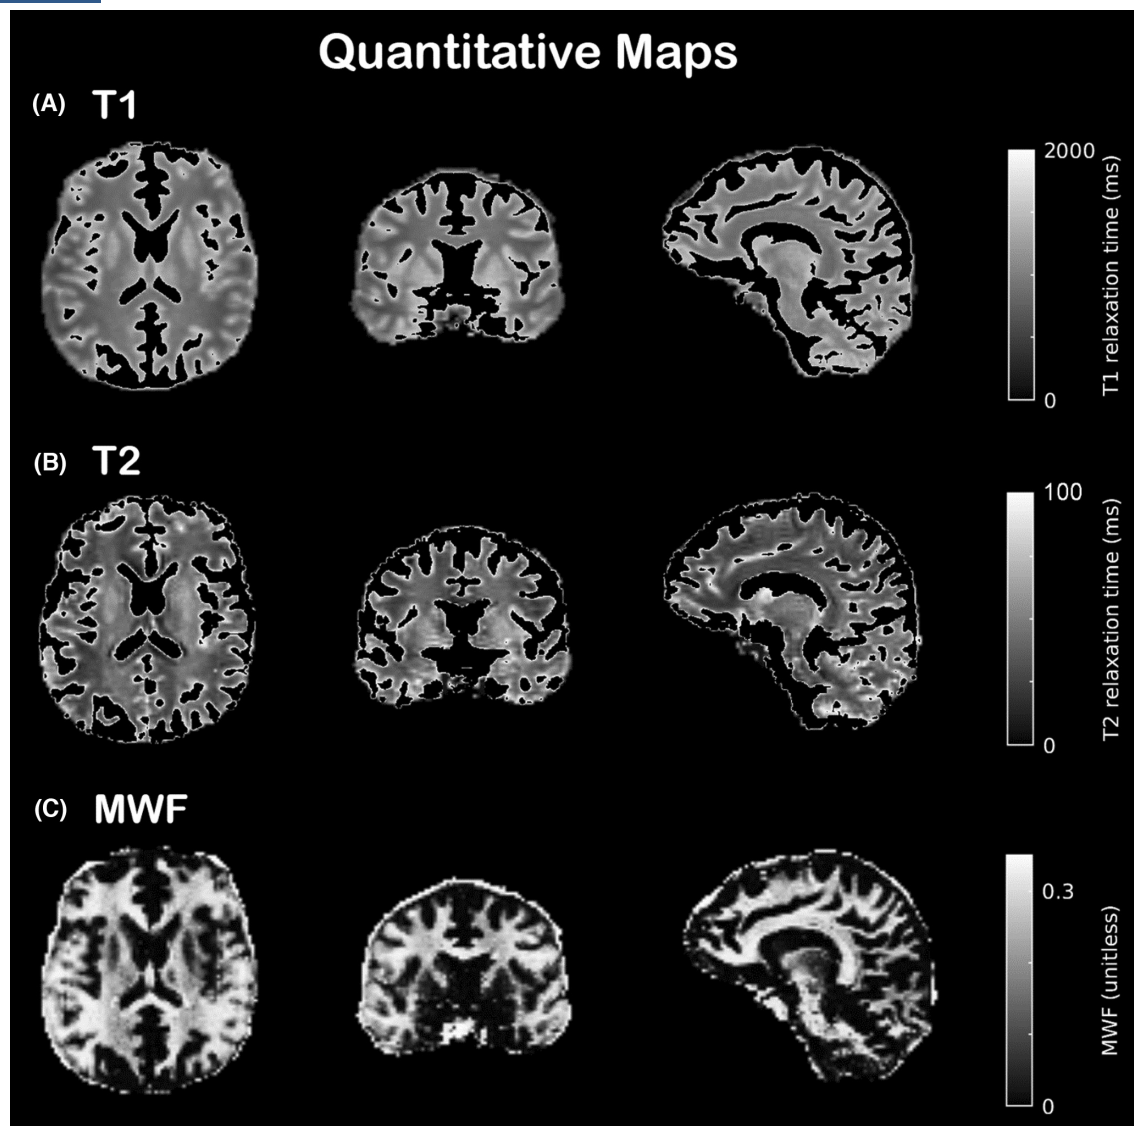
Representative axial, coronal and sagittal-oriented slices for quantitative magnetic resonance imaging maps. (A) T1 relaxation times; (B) T2 relaxation times; (C) myelin water fraction.
